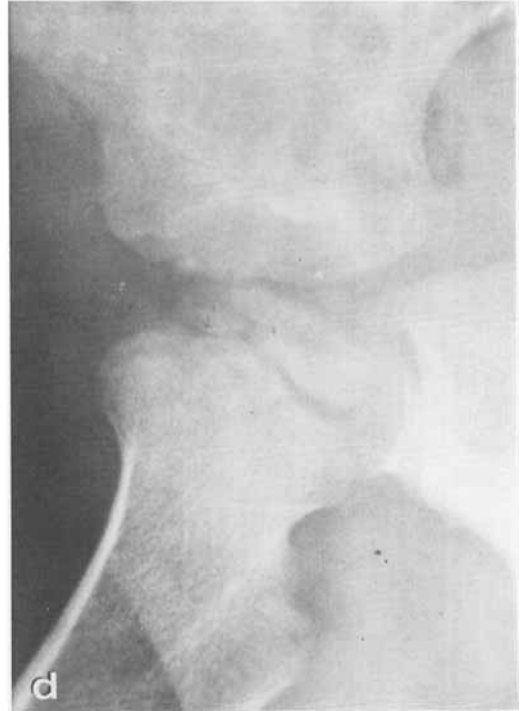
c, d. Radiographs taken 7 months after diagnosis. Irregularities in the density and outline of the capital epiphysis, but no separate fragment can be identified.
